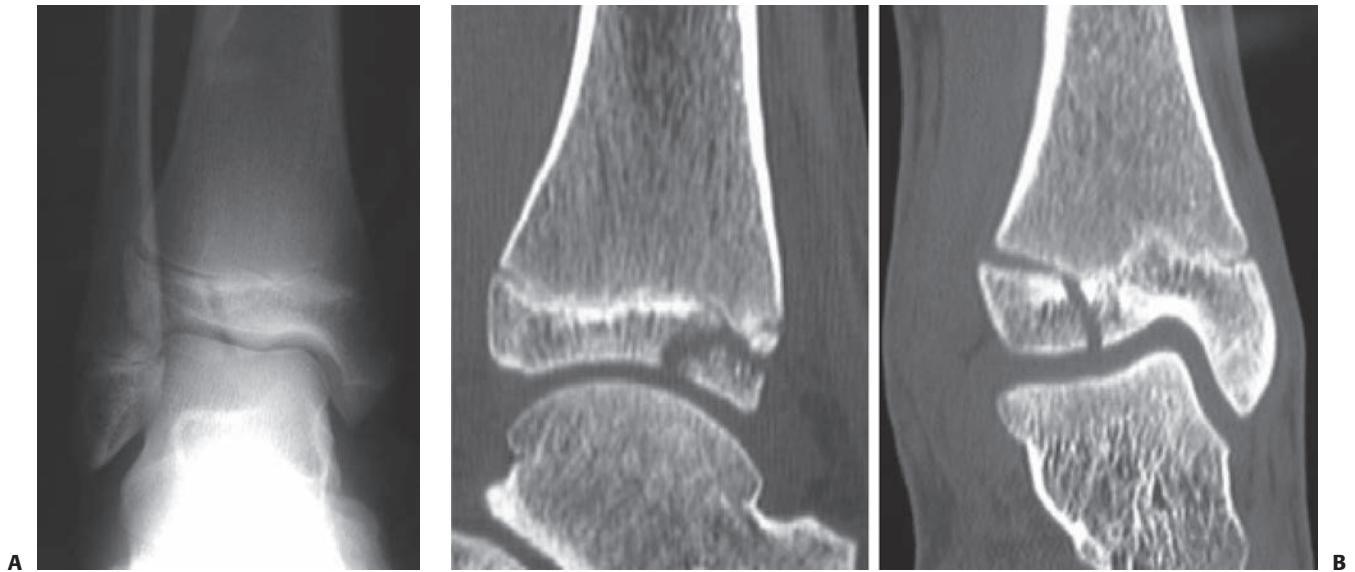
A: AP view demonstrating a Tillaux fracture with vertical, sagittal epiphyseal and horizontal, axial physeal components. B: Computed tomography is useful for defining transitional fracture pattern. In Triplane fractures there is a sagittal split (similar to that in Tillaux fractures) with a transverse fracture through the growth plate and an ascending coronal split up the metaphysis. (Property of UW Pediatric Orthopaedics.)
